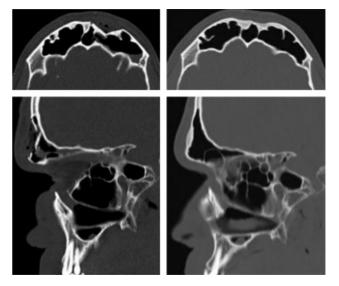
Left: preoperative axial and sagittal CT cuts of an anterior table fracture of the frontal sinus. Right: 2-year postoperative axial and sagittal CT cuts following transorbital endoscopic reduction. CT, computed tomography.
